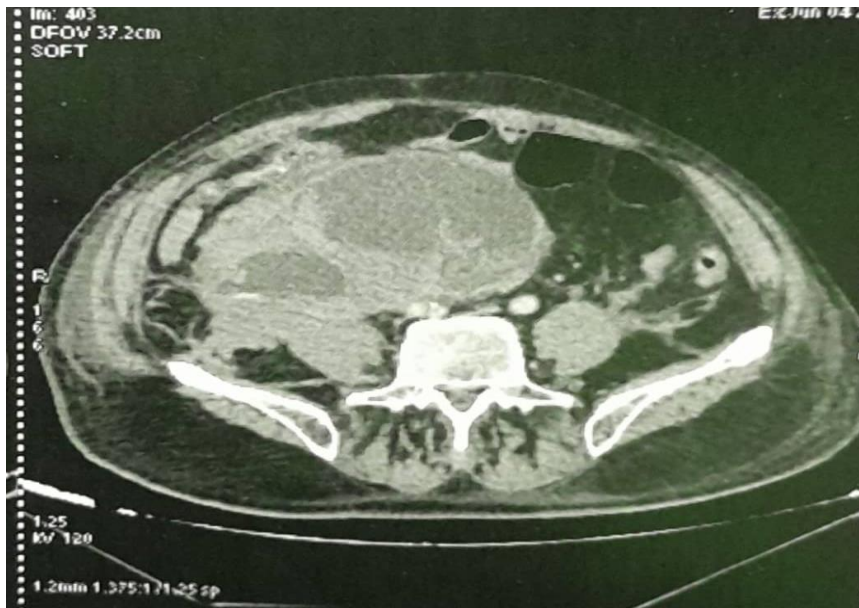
Thoraco-abdomino-pelvic CT scan showing a large intraperitoneal haematoma with no sign of pulmonary embolism. HMMI-Meknes Imaging Department
